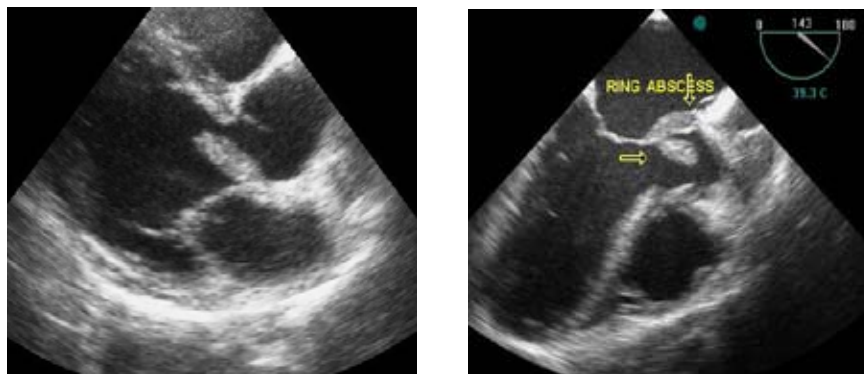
Left, transthoracic parasternal long-axis view showing very large smooth surface bulky vegetation on left coronary cusp of Aortic valve. Right, transesophageal long-axis view showing large vegetation and ring abscess (arrows).
